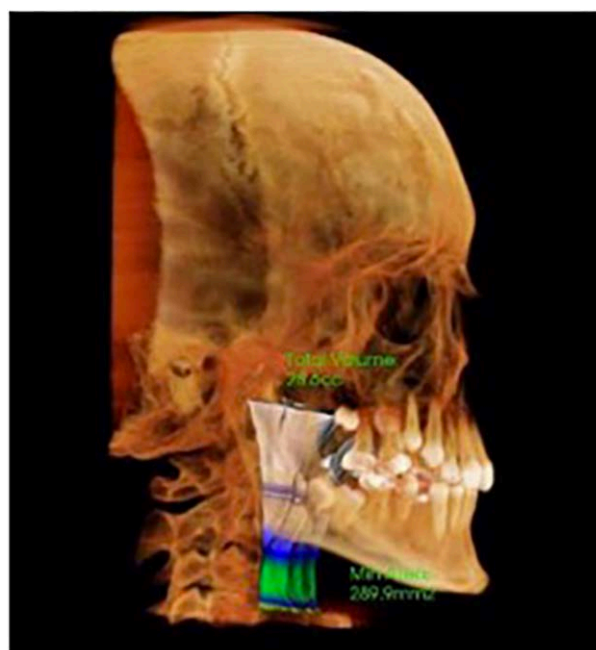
Example of an airway assessment using a CBCT in InVivo™ software.
